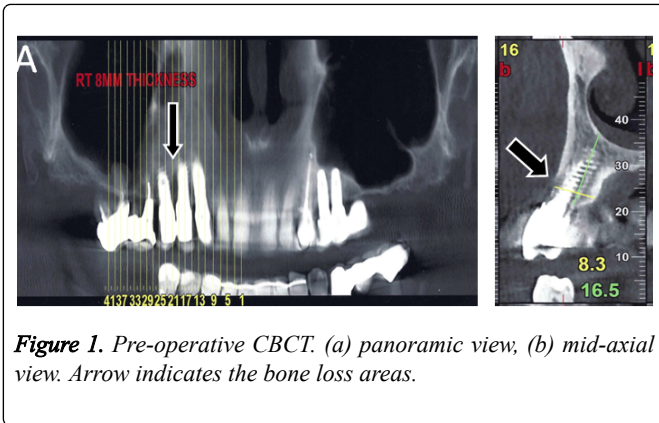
Pre-operative CBCT. (a) panoramic view, (b) mid-axial view. Arrow indicates the bone loss areas.
